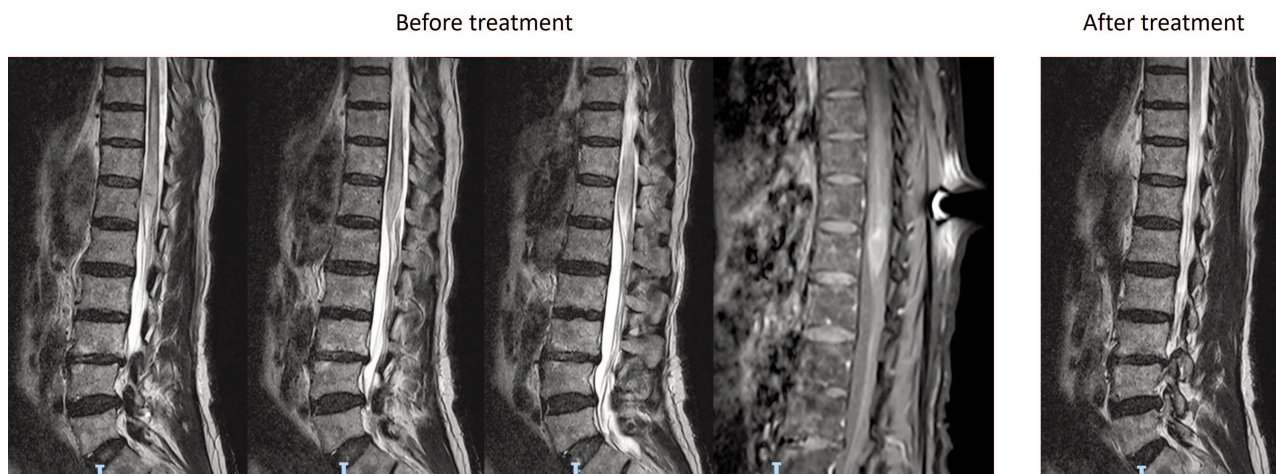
MRI of the whole spine showing a swollen lower dorsal region with abnormal low T1 high T2 signal intensity opposite to the level of D12 up to the level of D10 (left images before treatment) and a repeat MRI of the whole spine showing regressive course of the cord expansion and abnormal high T2 signal seen at the distal 3 segments of the spinal cord (right image after treatment)
